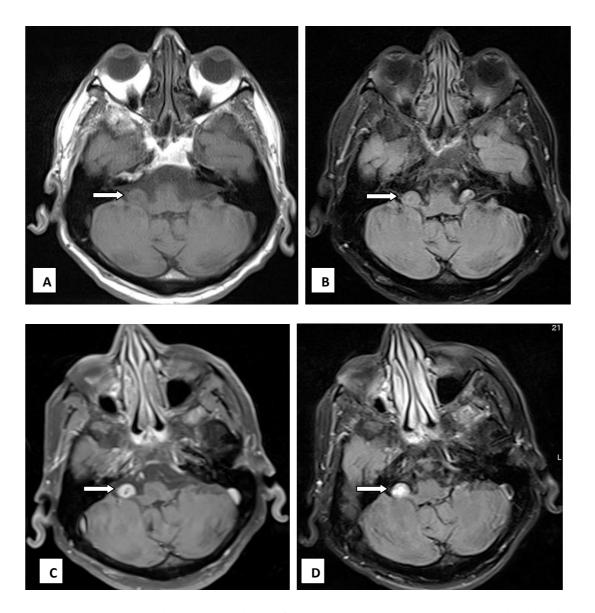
MRI brain axial sections of a 74-year-old male presented with tinnitus and post imaging was diagnosed with vestibular schwannoma on right side. (A) T1WI & T2 FLAIR image showed a well circumscribed, heterogeneously hypointense lesion in right cerebello-pontine angle. The lesion demonstrates better enhancement on (D) T2 FLAIR PC image than (C) T1 FS PC. The limitation of the study seen in this case: Cystic component in the lesion shows hyperintensity which makes it difficult to differentiate from enhancement.
